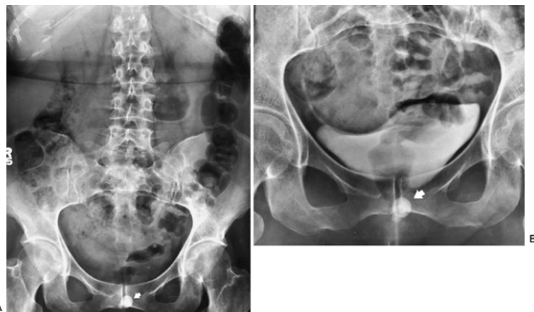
7. A: The preliminary radiograph should include area from kidneys to pubic symphysis. Calcification overlying pubic symphysis (arrow) is a calculus within a urethral diverticulum. B: Coned-down bladder radiograph following contrast media injection demonstrating urethral diverticulum. The urethral calculus would have been missed if the radiograph before contrast injection did not include the pubic symphysis.
